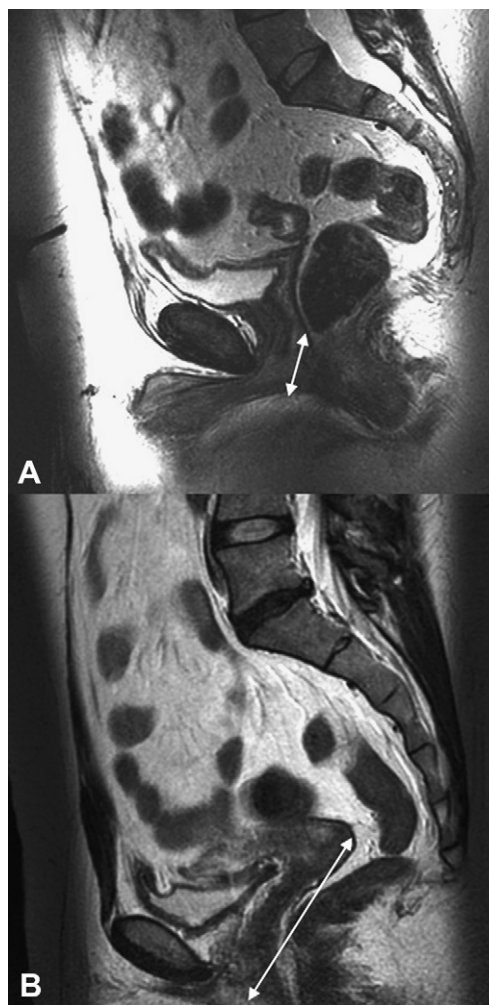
(A) CAIS vaginal depth 3.26 cm, (B) control vaginal depth 7.8 cm, as demonstrated on MRI.
